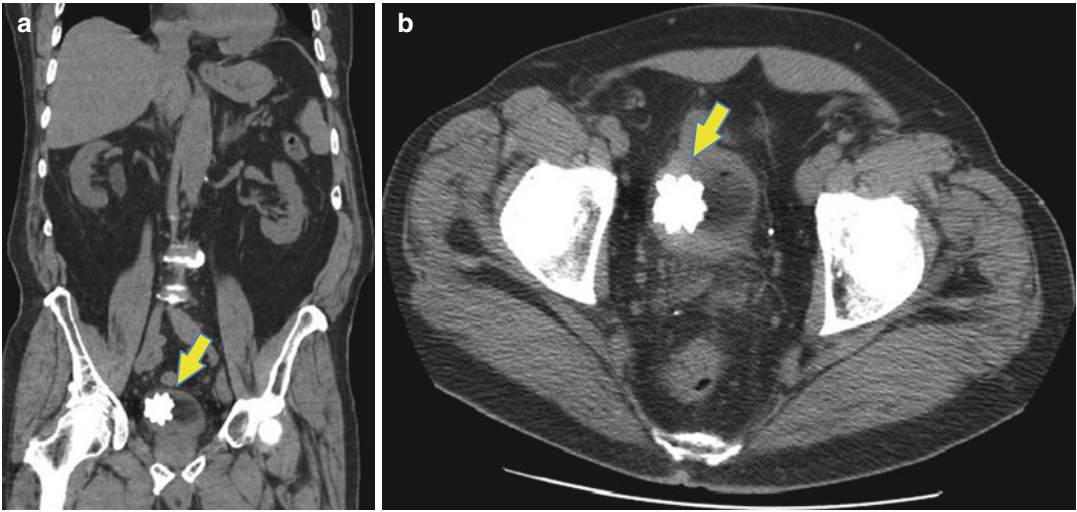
Coronal (a) and axial (b) CT scan images of a large bladder stone (yellow arrow) in a patient with urinary retention secondary to an enlarged prostate
